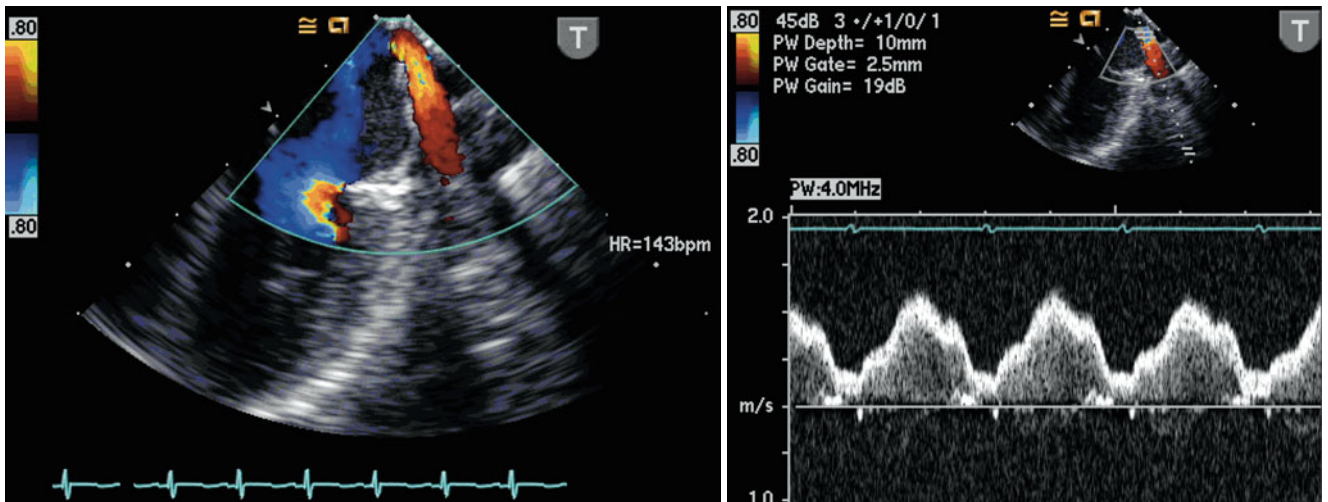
Color flow Doppler imaging (*left panel*) and spectral tracing (*right panel*) complements the two-dimensional evaluation of the pulmonary veins. Note the characteristic normal systolic and diastolic nature of the pulmonary venous flow
